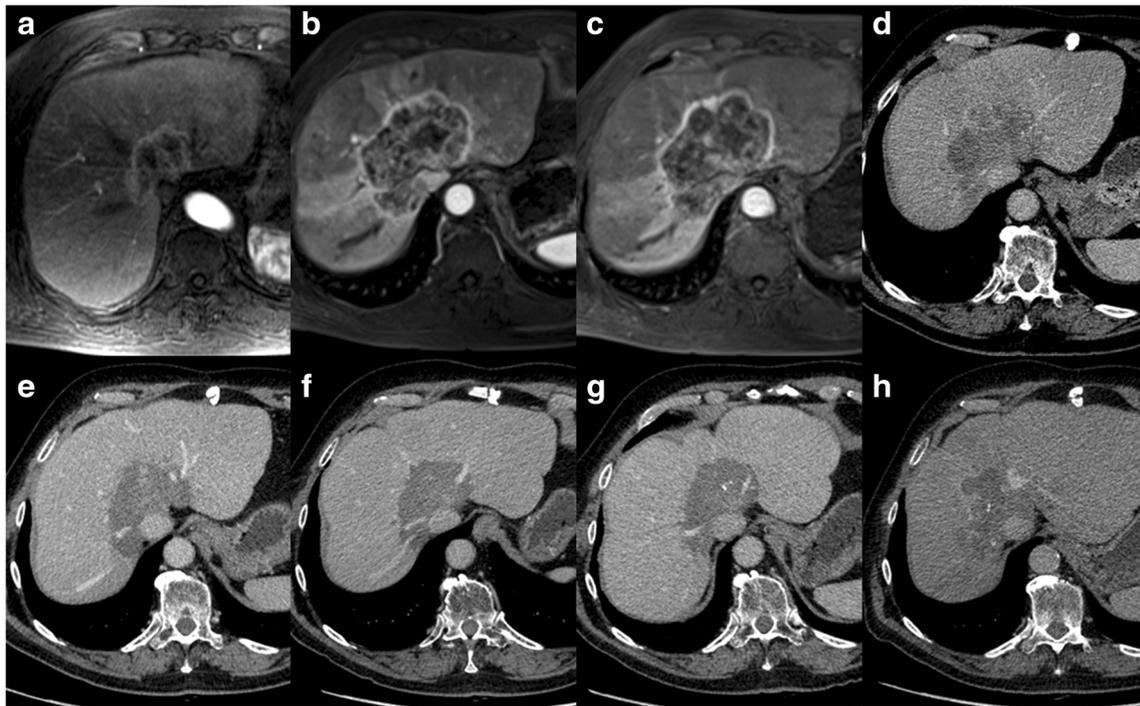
A 76-year-old male patient with intrahepatic cholangiocarcinoma. MRI at the time of first diagnosis showing an intrahepatic tumour with peripheral enhancement (a). Progressive disease after 34 months of conventional chemotherapy (b). MRI after first percutaneous hepatic perfusion (PHP) (c) and CT after second (d), third (e) and fourth (f) treatment
